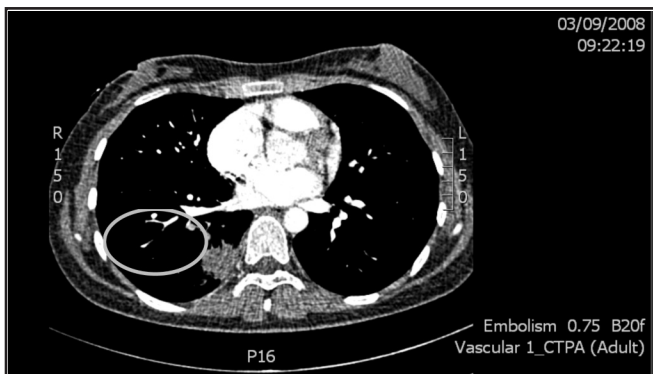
CT pulmonary angiogram shows filling defects in the subsegmental pulmonary arteries of the right lower lobe, confirming the diagnosis of pulmonary embolism; with consolidation in the corresponding region.
